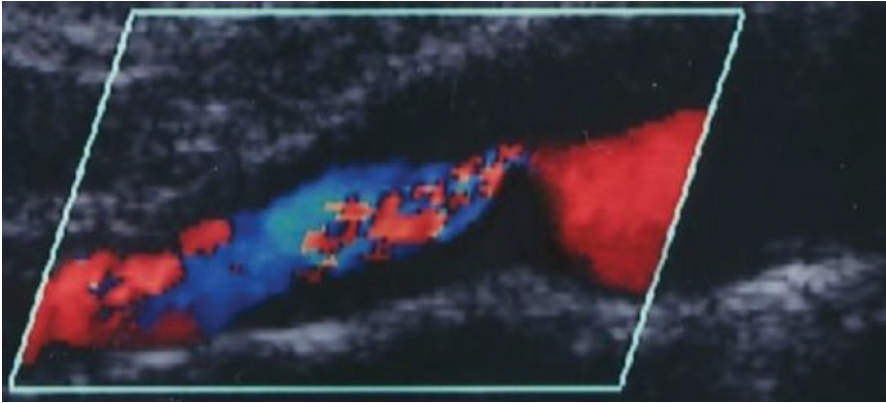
Echocolor Doppler US: soft plaque
